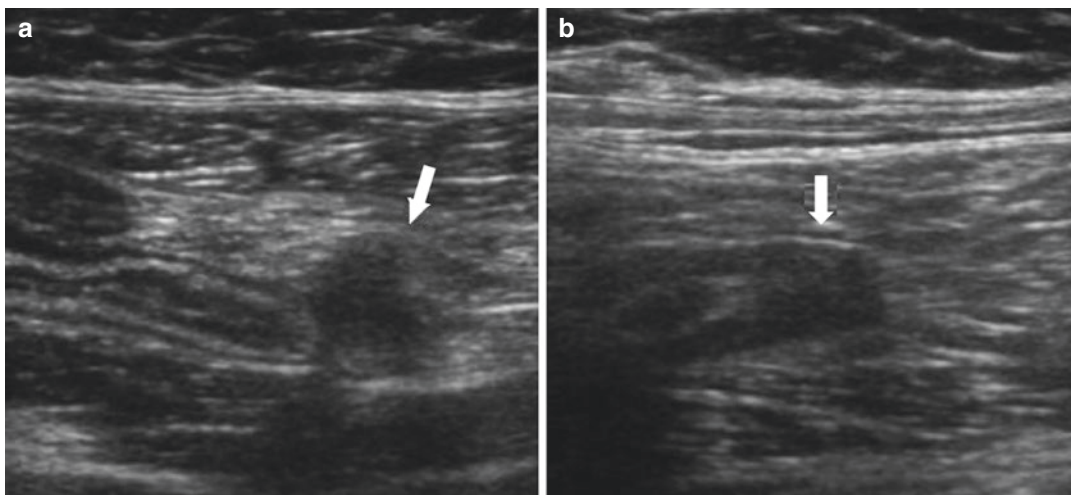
Suprapubic ultrasound with high-resolution linear transducer: nodular thickening at the tip of the appendix (arrows), being endometriosis in (a) and carcinoid tumor in (b)
